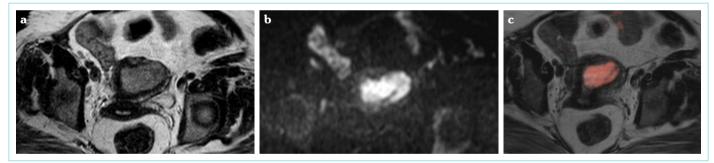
Axial oblique T2WIs (a) with an endometrial mass of intermediate signal intensity is seen distending the endometrial cavity with the deep myometrial invasion at the fundus with an intact serosal surface. This was confirmed by Axial oblique DWI at a b value of 1000 (b) and a T2/DW fused image (c) (Stage IB)
